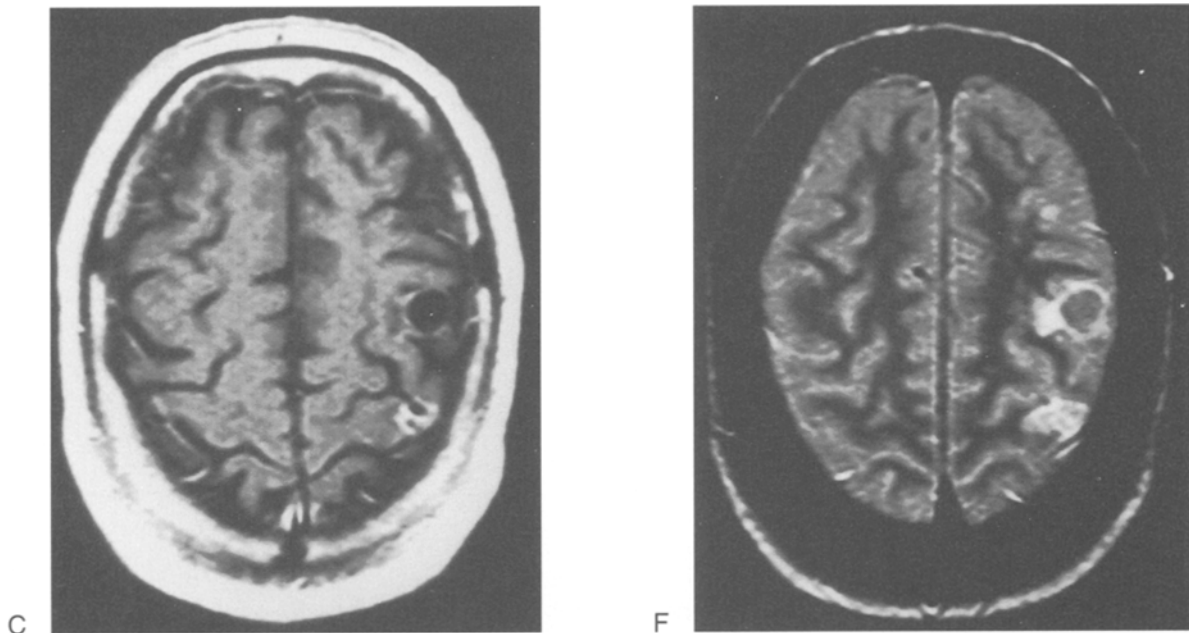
Axial MR images through a selected level of the brain, showing 3 metastases before radiotherapy (RT) and the response after radiotherapy. (a–c) short TR images, (d–f) long TR images: (a, d) before RT, (b, e) 4 weeks after RT, (c, f) 15 weeks after RT. After 4 weeks a marked decrease of edema and enhancing tumor mass is seen. Only at 15 weeks tumor mass has nearly disappeared and substantial necrosis has developed.
